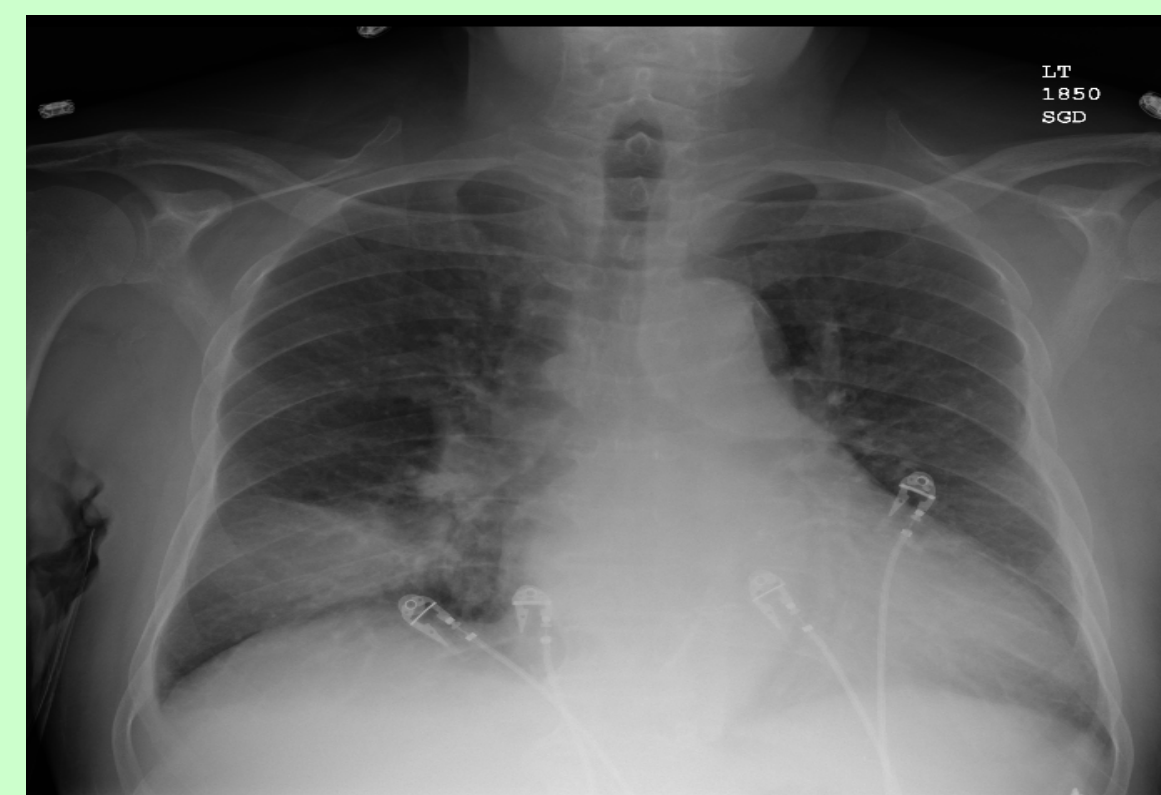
Chest radiograph from second admission showing interval worsening of right lung infiltrate
